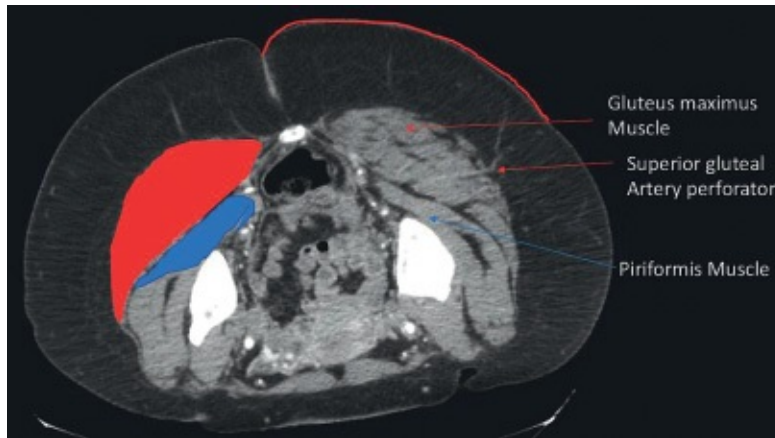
• Locations of SGAP perforator on axial CT scan including the gluteus maximus muscle and piriformis muscle.
